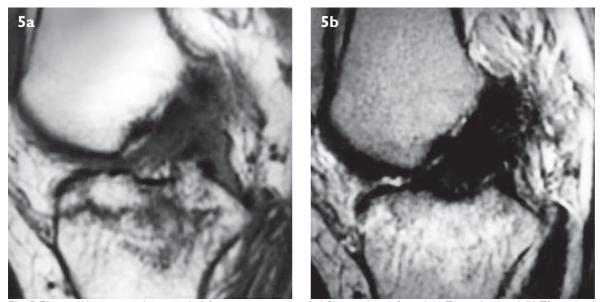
71-year-old woman with upper tibial fracture associated with ACL partial tear. Sagittal (a) T1-weighted and (b) T2-weighted MR images show a tibial condylar subchondral fracture that extends to the articular surface. Extensive surrounding bone bruising is well depicted, particularly on T2-weighted images. The ACL is grossly swollen but intact, consistent with a partial ACL tear.
